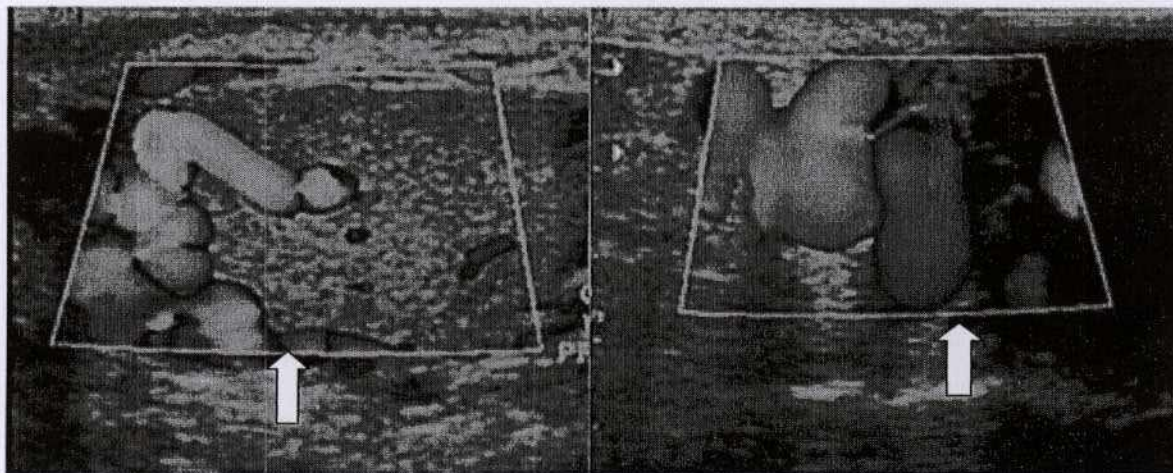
(A) Intratesticular varicocele in a 42-year-old man. Color Doppler US scan shows flow within the tubular structures. (B) Extratesticular Varicocele in a 22 year-old man. Color Doppler US scan shows flow within the tubular structures in the anterior and upper portion of the testis
